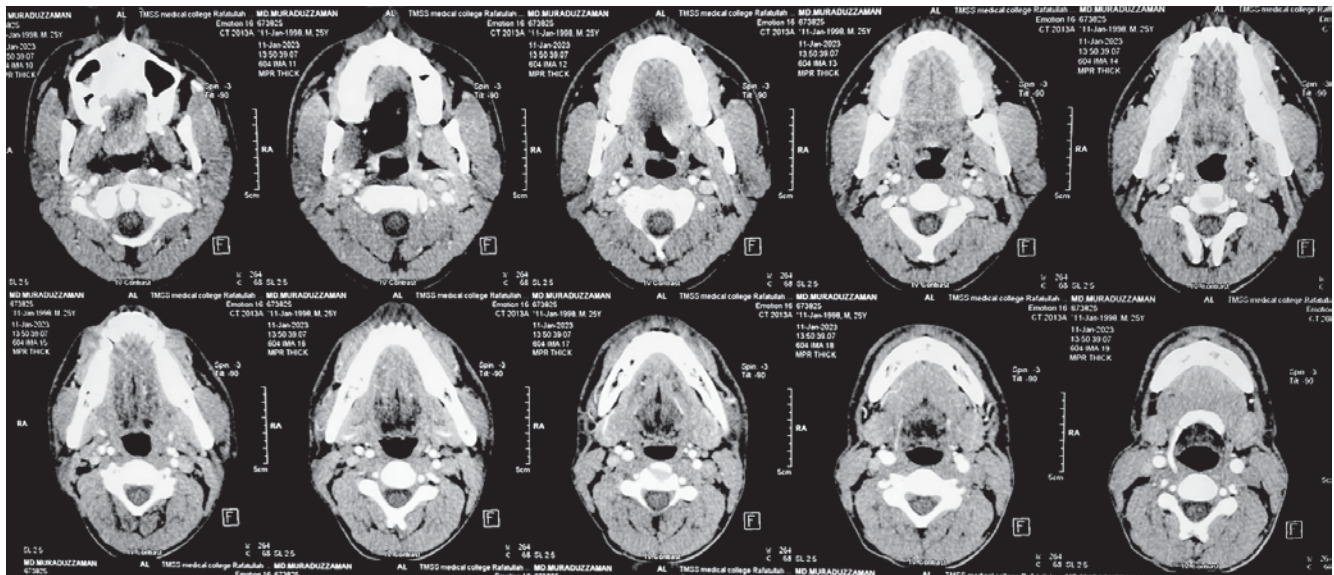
CT scan of Neck shows soft tissue mass in left parotid region.
